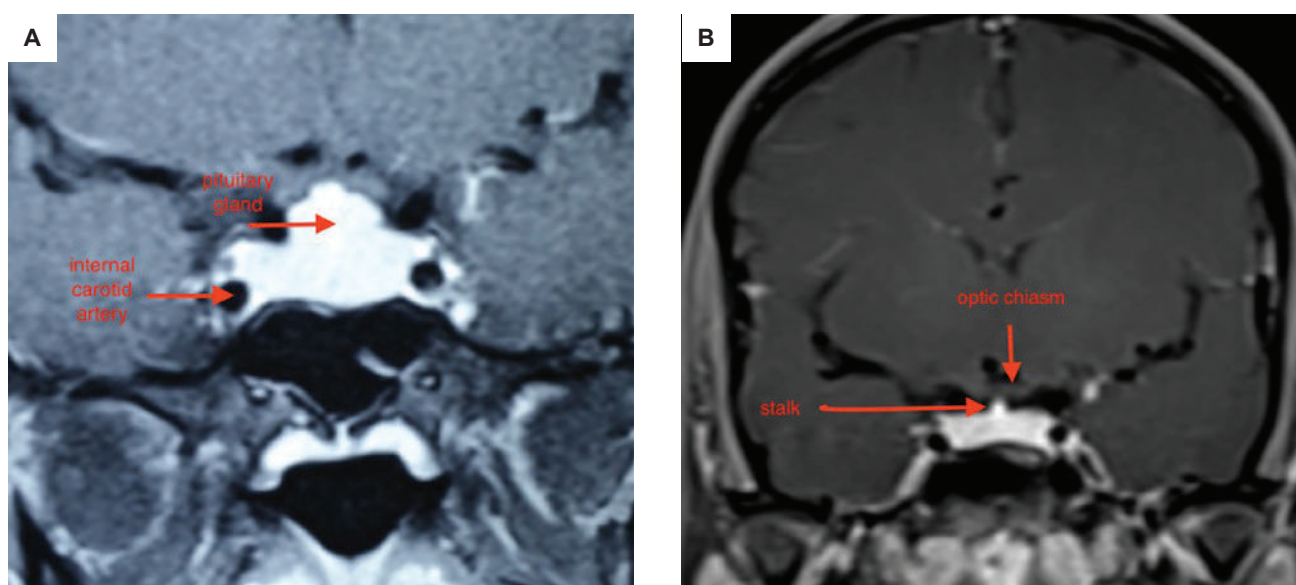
(A) Coronal post contrast T1-weighted image showing pituitary enlargement with dome-shaped convexity. (B) Coronal post contrast T1-weighted image showing lesion disappearing 6 months after levothyroxine supplementation.
